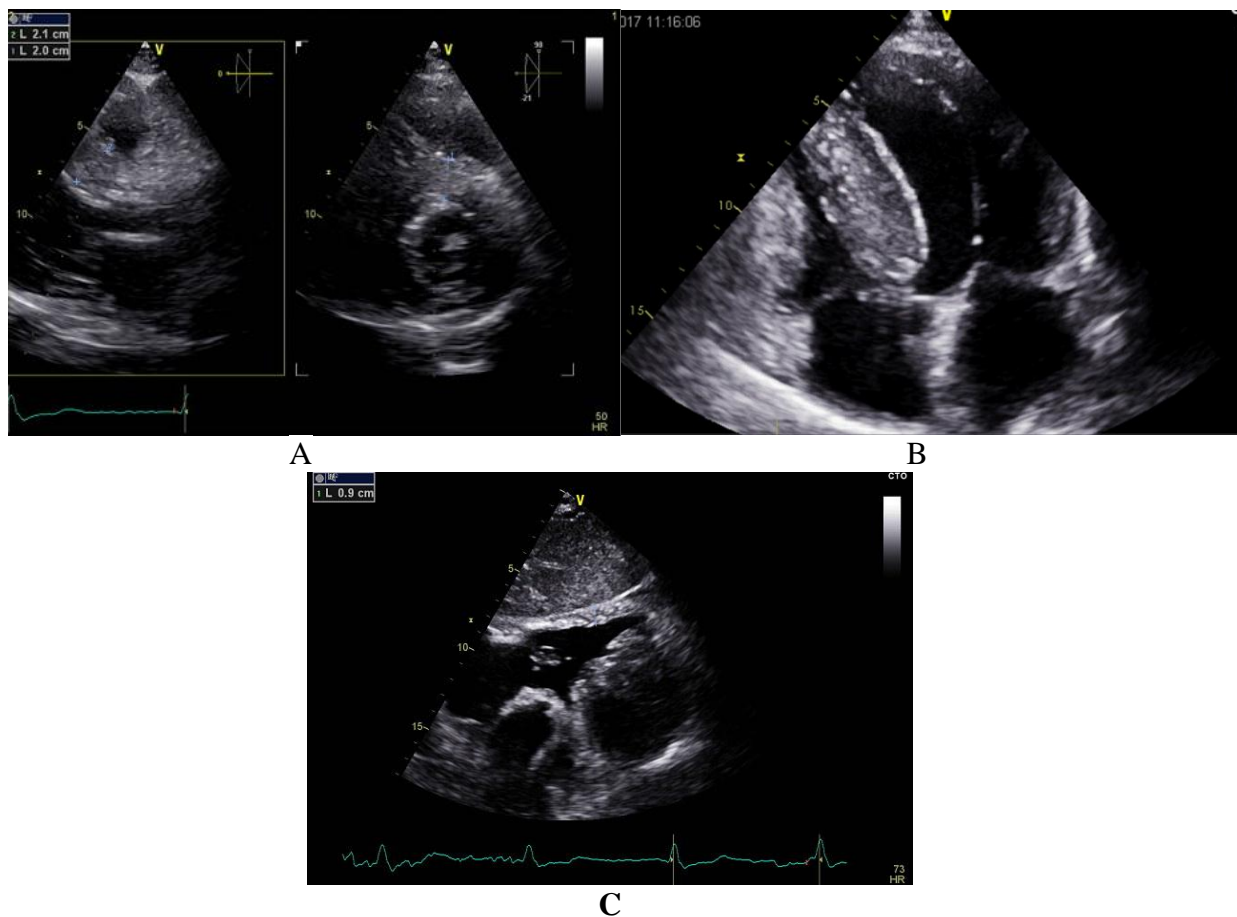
A: Parasternal long and short axis views with with measurements of left ventricle dimensions, B: Apical 4 chamber view showing sparkled interventricular septum, C: subcostal 4 chamber view displaying right ventricular hypertrophy.
